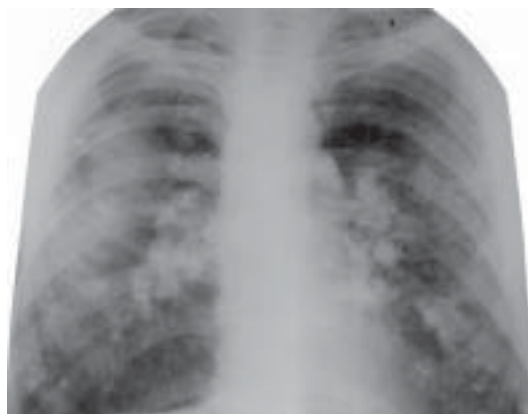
Silicotuberculosis: III stage silicosis, disseminated lung tuberculosis, infiltration phase. Observation roentgenogram.
